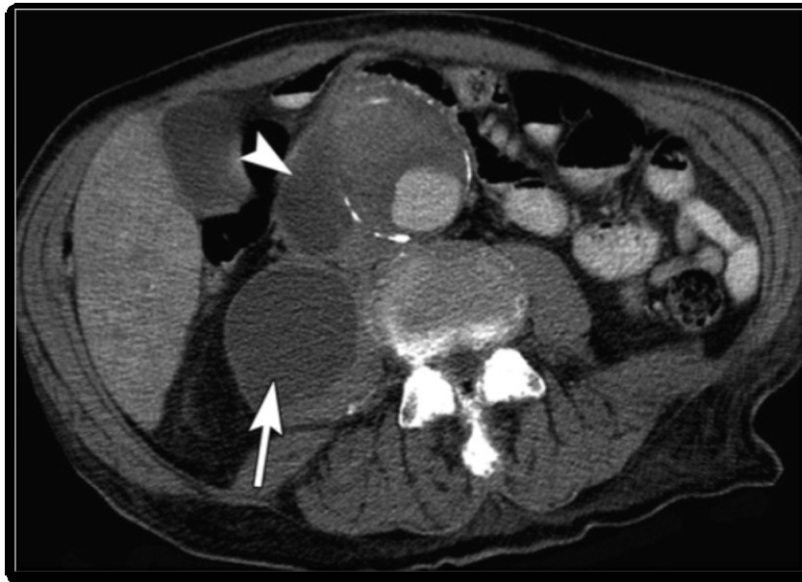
Contrast-enhanced axial CT of a ruptured AAA. The image displays a retroperitoneal hematoma (arrowhead) and a right-psoas hematoma (arrow). Adapted from Rakita et al. (2) Authorized reproduction.
